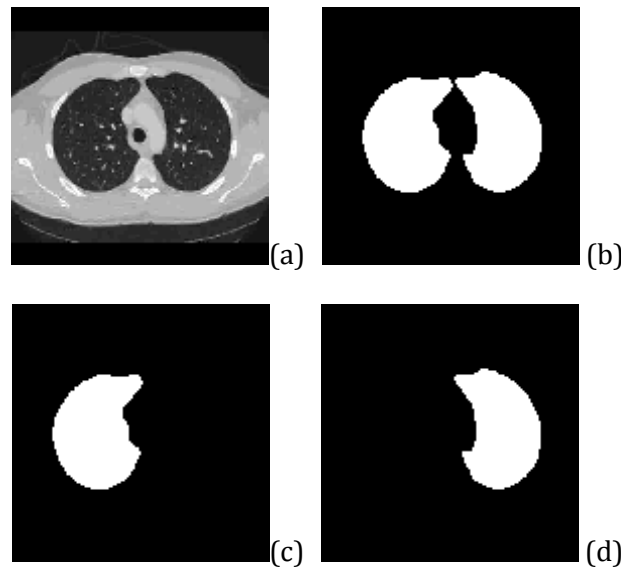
A CT image slice of the reference lung: (a) examination scan; (b) binary image of pulmonary region; (c) binary image of right lung and (d) binary image of left lung.
